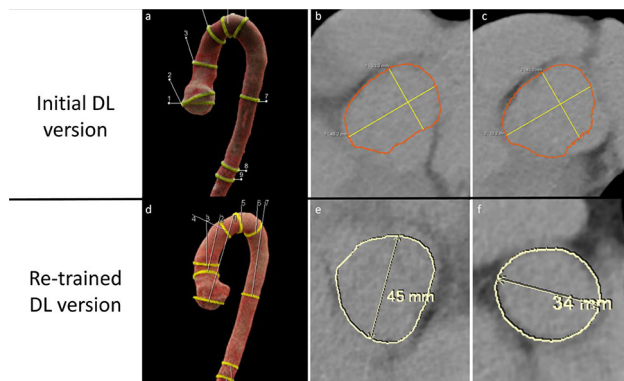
Case of diameter assessment in a non-CE chest CT performed by the initial (a-c) and re-trained DL tool (d-f). VRT (a) and through-plane view at AS (b) and STJ (c) showed tilted planes at AS (b) and STJ (c) landmarks. In the re-trained version, segmentation at STJ was correct (= improved) (f); AS (e) was still tilted and therefore false
